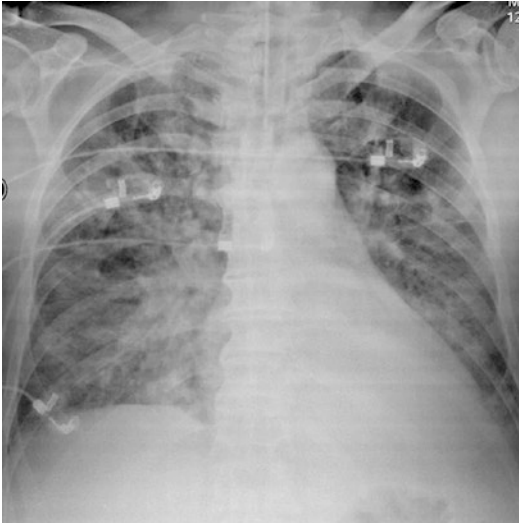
Chest radiograph shows multiple bilateral lobular areas of consolidation of pulmonary parenchyma that coalesce in the right paracardiac region
